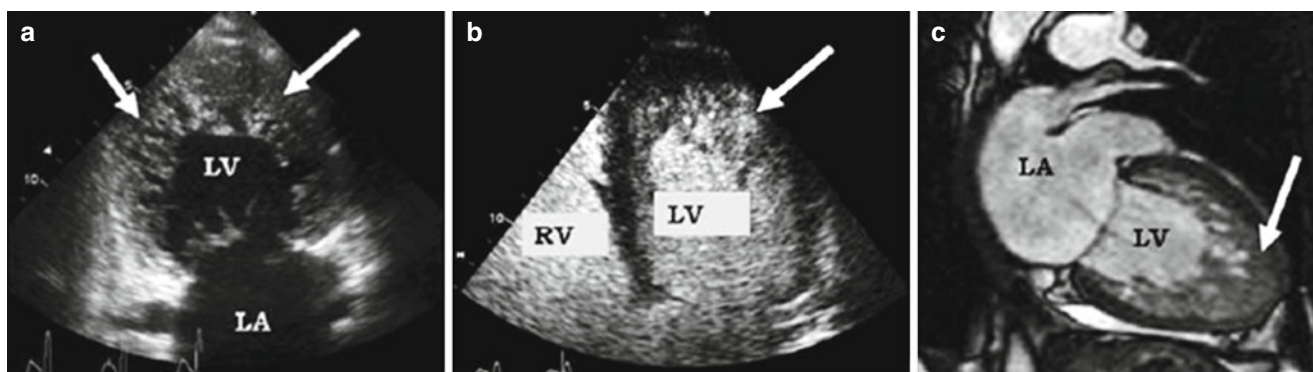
Various imaging modalities used to demonstrated LVNC with the arrows highlighting the trabeculations. Transthoracic echocardiography (a), contrast echocardiography (b), DE-MRI (c), and 3D echocardiography (d). The explanted heart is shown in (e)
